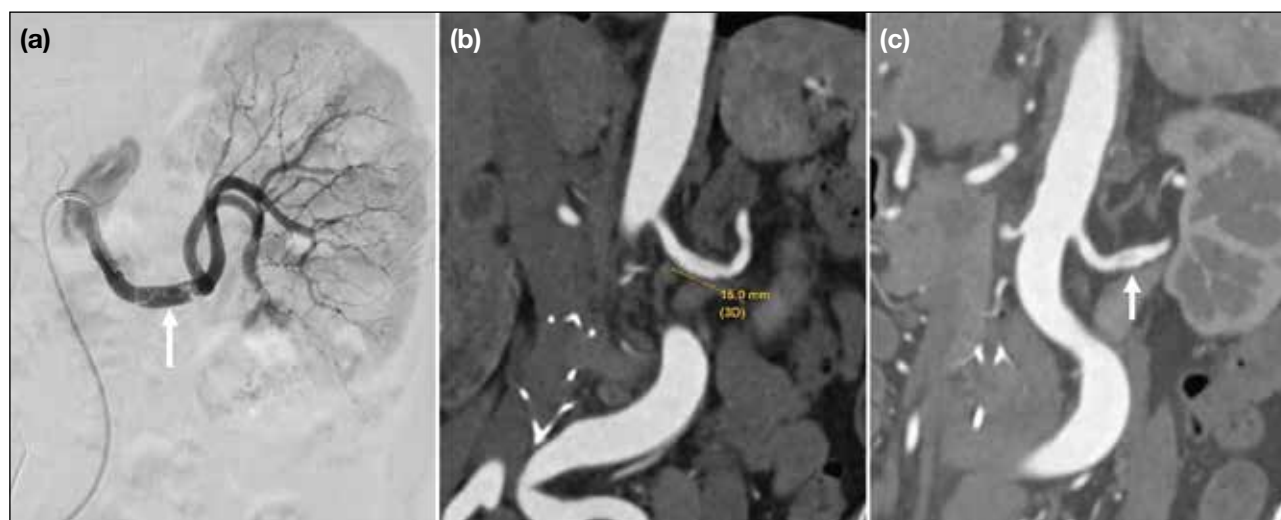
A 68-year-old female patient with left renal transcatheter arterial embolisation complicated by renal artery dissection. (a) Post-embolisation angiogram showing a small dissection (1.5 cm long and 0.2 cm wide) in the left main renal artery (arrow). Conservative management was decided upon. Sagittal reformatted of follow-up computed tomography the next day (b) and after 15 months (c) showed that the dissection remained unchanged (arrow in [c]).
